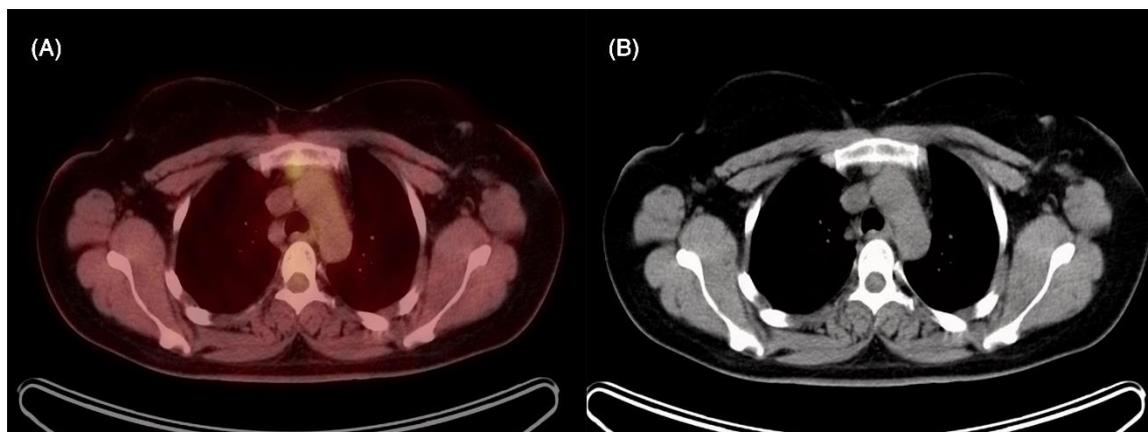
PET/CT fusion and axial CT images reveal a lymph node with increased FDG uptake in the prevascular space
